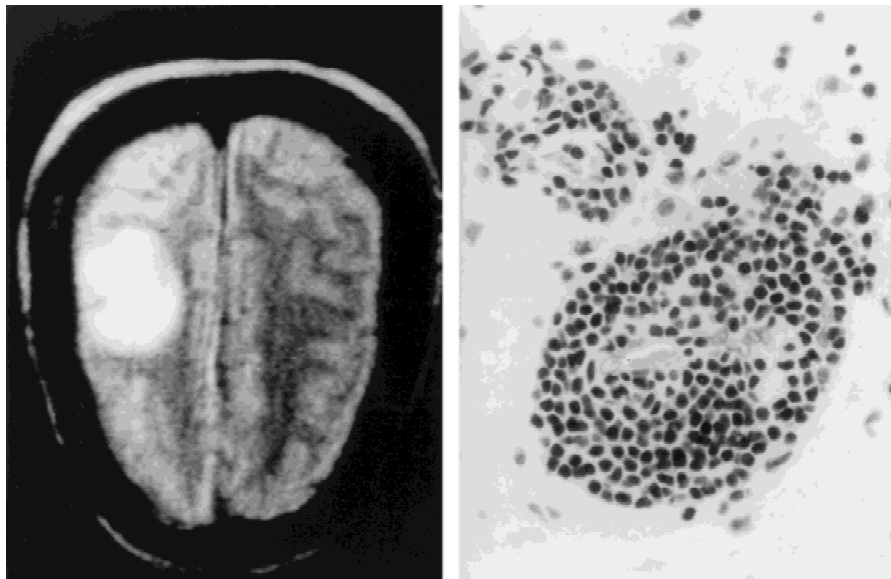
Left: MRI of brain with T2 showing a hyperintense lesion in left fronto-parietal subcortical area. Right: Perivascular lymphocytic infiltrate.
